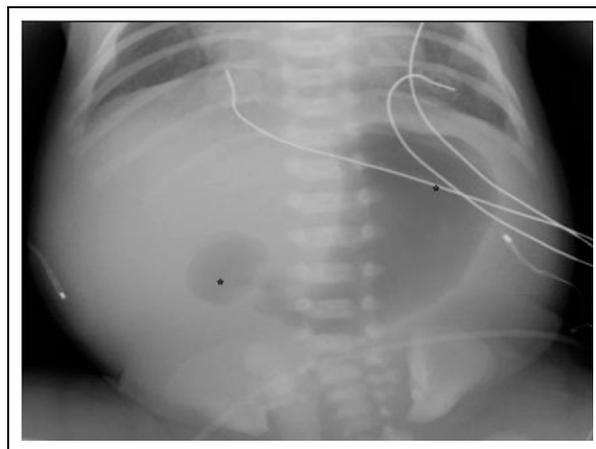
Plain abdomen radiograph showing double bubble sign suggestive of duodenal atresia.
